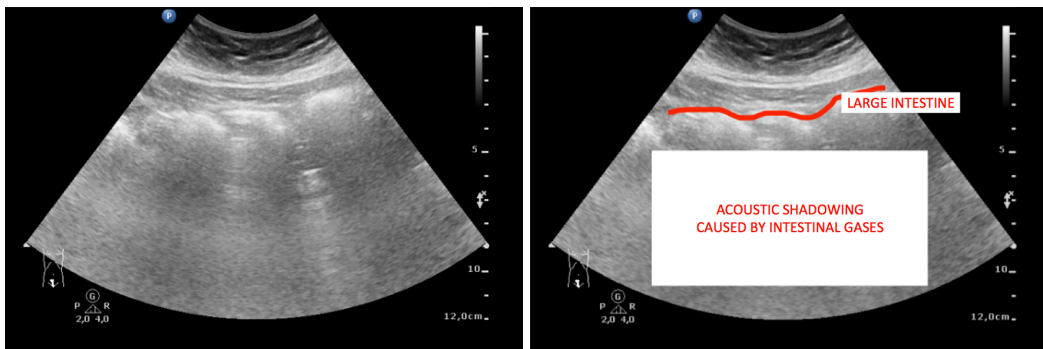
Ultrasonographic image of the large intestine with significant acoustic shadowing caused by intestinal gases.
